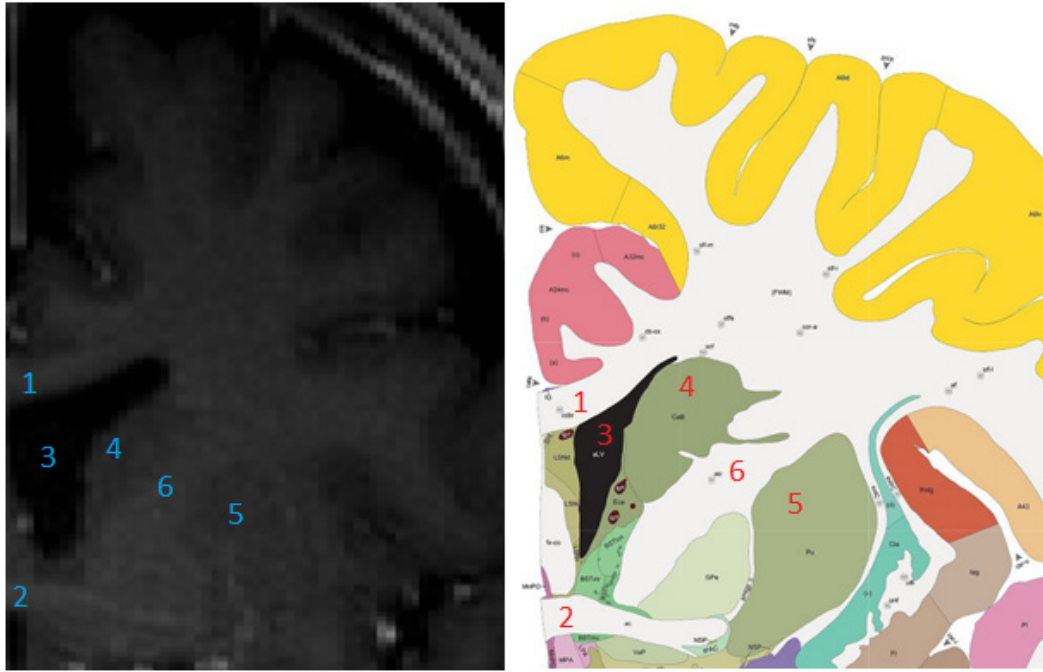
T1 weighted 3 T MRI image from the coronal plane on the left and the corresponding atlas representation on the right. Some clearly distinguishable structures marked in the images from 1 to 6. 1. Corpus callosum. 2. Anterior commissure. 3. Lateral ventricle. 4. Caudate nucleus. 5. Putamen. 6. Internal capsule. Adapted from [25].*
